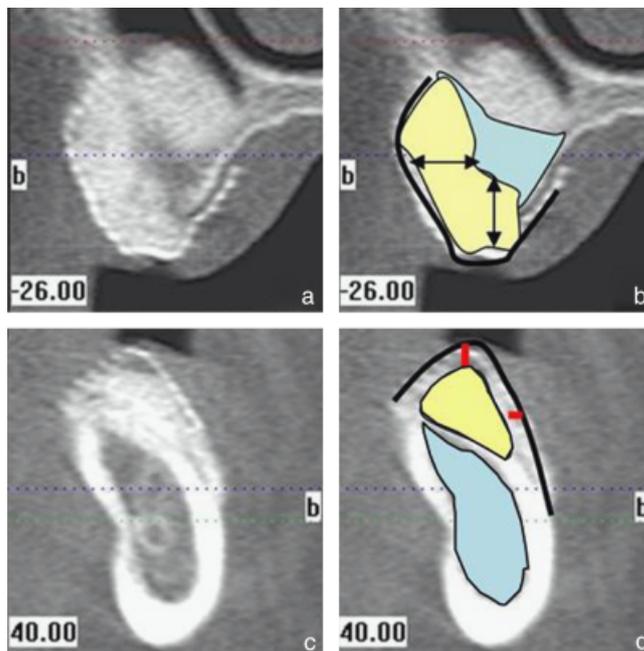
CT images of maxillary (a, b) and mandibular (c, d) ridge augmentation showing the residual ridge (blue), the augmented area (yellow) the Ti-mesh (black line), and the radiolucent space beneath the Ti-mesh (red arrows).
